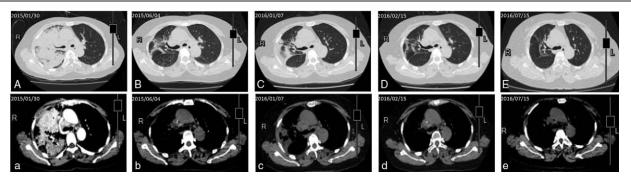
Chest CT images from Jan 30, 2015 to July 15, 2016. (A and a) The chest CT scan on admission displayed extensive consolidation in the right upper lung, with enlarged mediastinal lymph nodes. The extensive consolidation in the right upper lung presented uneven enhancement on the enhanced CT scan, whereas the densities of the enlarged mediastinal lymph nodes were enhanced evenly. (B and b) The chest CT scan after the first time treatment for *T. marneffei* showed that pulmonary consolidation was absorbed partly. (C and c) The chest CT scan after ultrasound-guided thoracentesis demonstrated the progressed consolidation of right lung at the second admission. (D and d) The chest CT scan performed during the follow-up period in our Respiratory Clinic showed that the consolidation was almost absorbed.
